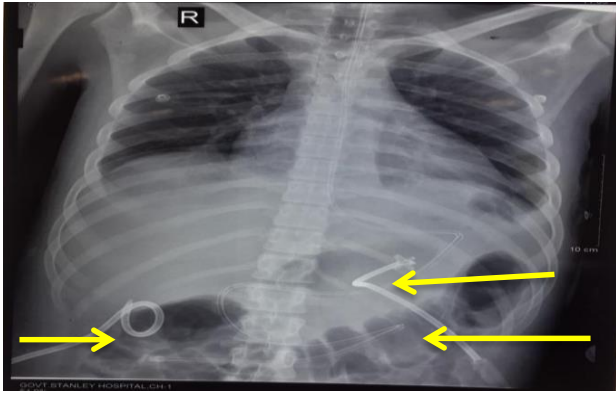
X-ray chest showing pigtail insitu in perihepatic space and in lesser sac with nasojejunal tube, left pleural effusion present.
